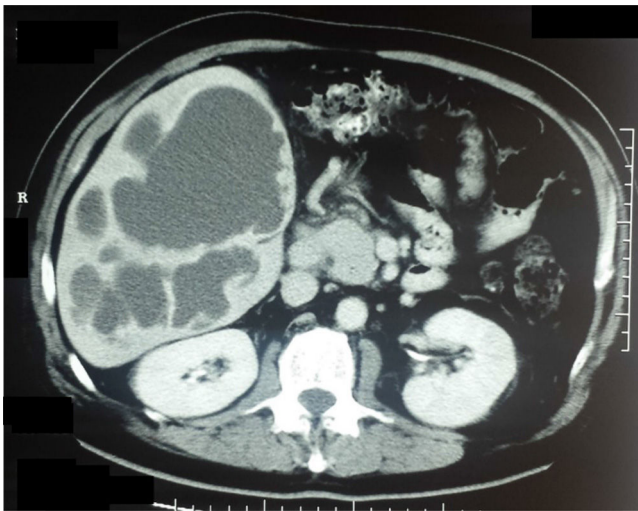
Axial view of a double-contrast computed tomography scan showing: an enlarged liver with multiple cystic lesions of 18 Hounsfield units (thick fluid), corresponding to amoebic liver abscesses.
